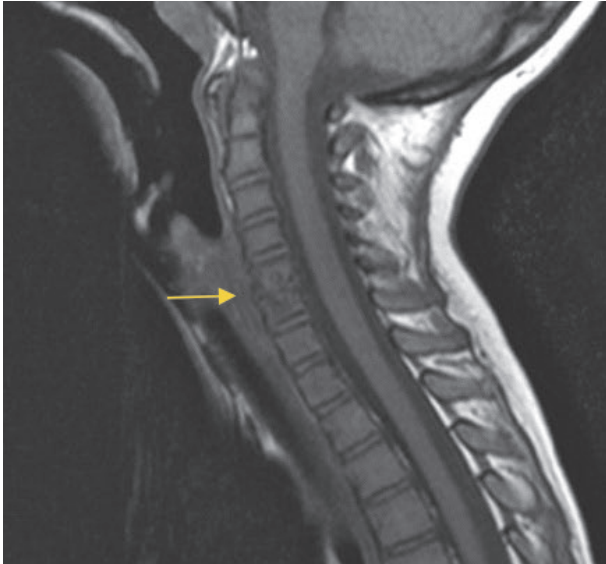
Sagittal plane of cervical magnetic resonance imaging showing a hypo-intense focal area in C5-C6 intervertebral disc (arrow).
